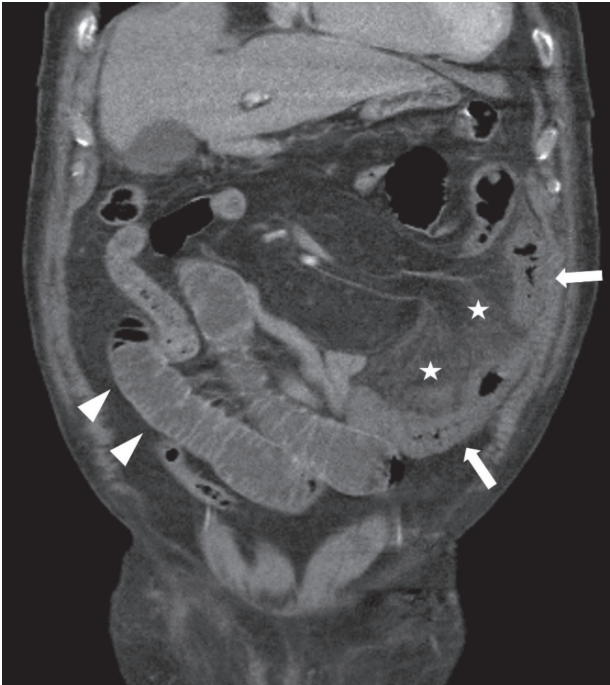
Monophasic whole-abdominal computed tomography with IV contrast is shown in the coronal plane, ischemic loops of the small bowel with diffuse wall thickness increase and no enhancement in the left abdominal quadrant (arrows). Marked edema and contamination are observed in the mesenteric fat planes surrounding the ischemic loops (stars). Dilated loops with normal wall enhancement compared to the ischemic loops are seen in the right abdominal quadrant (arrowhead).
